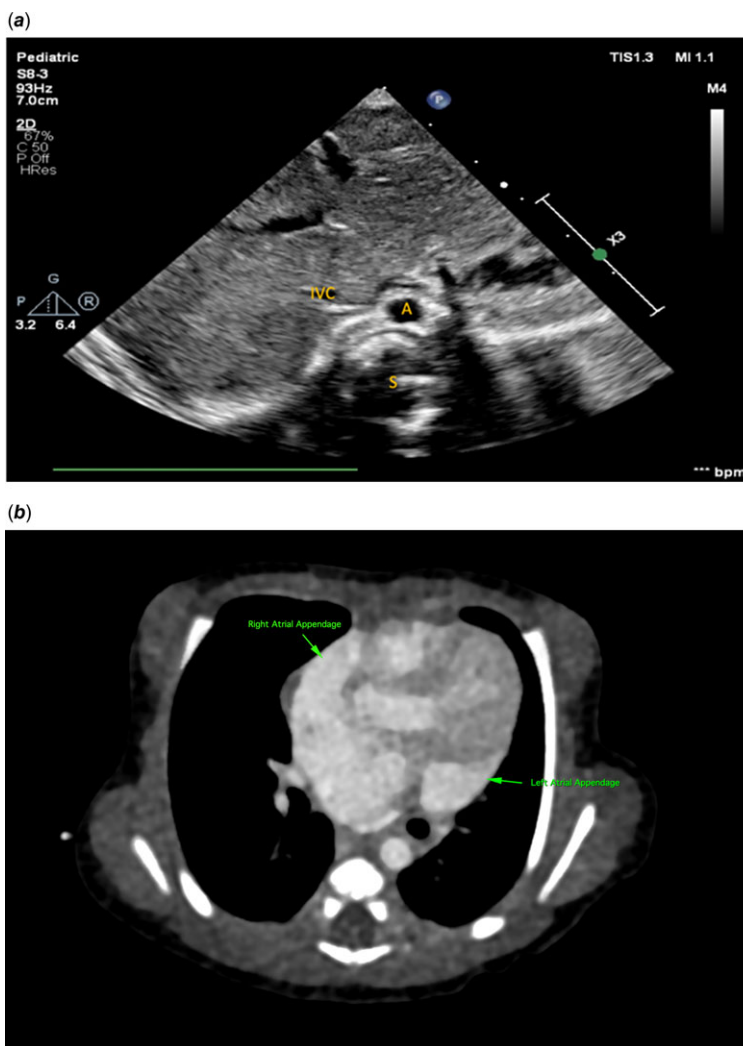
(a) Transthoracic subcostal echocardiography showing normal situs solitus. A: aorta, S: spine, IVC: inferior vena cava. (b) Chest computerized tomography in cross section showing the right and left atrial appendages. (c) Chest computerized tomography in coronal section showing the bronchial arrangement. (d) Transthoracic echocardiogram showing bicaval and hepatic vein connections to left atrium. SVC: superior vena cava, LA: left atrium, RA: right atrium, HV: hepatic veins, IVC: inferior vena cava.
